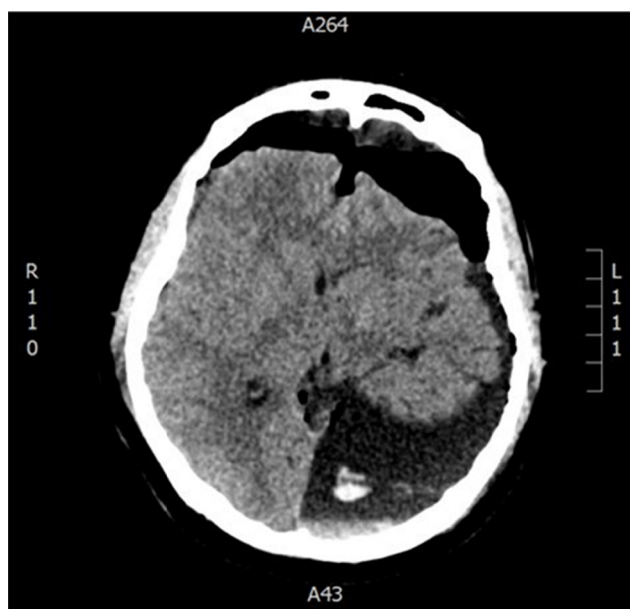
Post operative CT scan.
